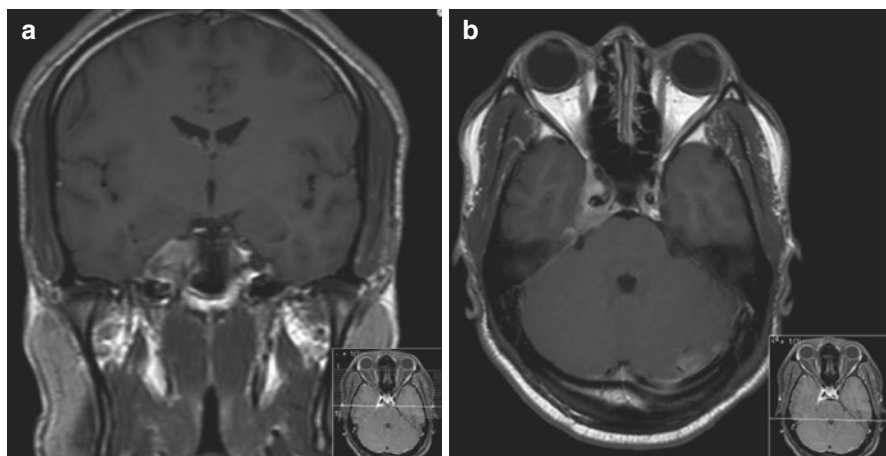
MRI: (a) T1 weighted axial scan showing an expansile lesion contiguous with the meninges arising from the right cavernous sinus and extending into Meckel's cave, along the petrous ridge and as far as the pre-pontine cistern, which enhances (b). On the left there is additional meningeal enhancement adjacent to the temporal and occipital lobes
